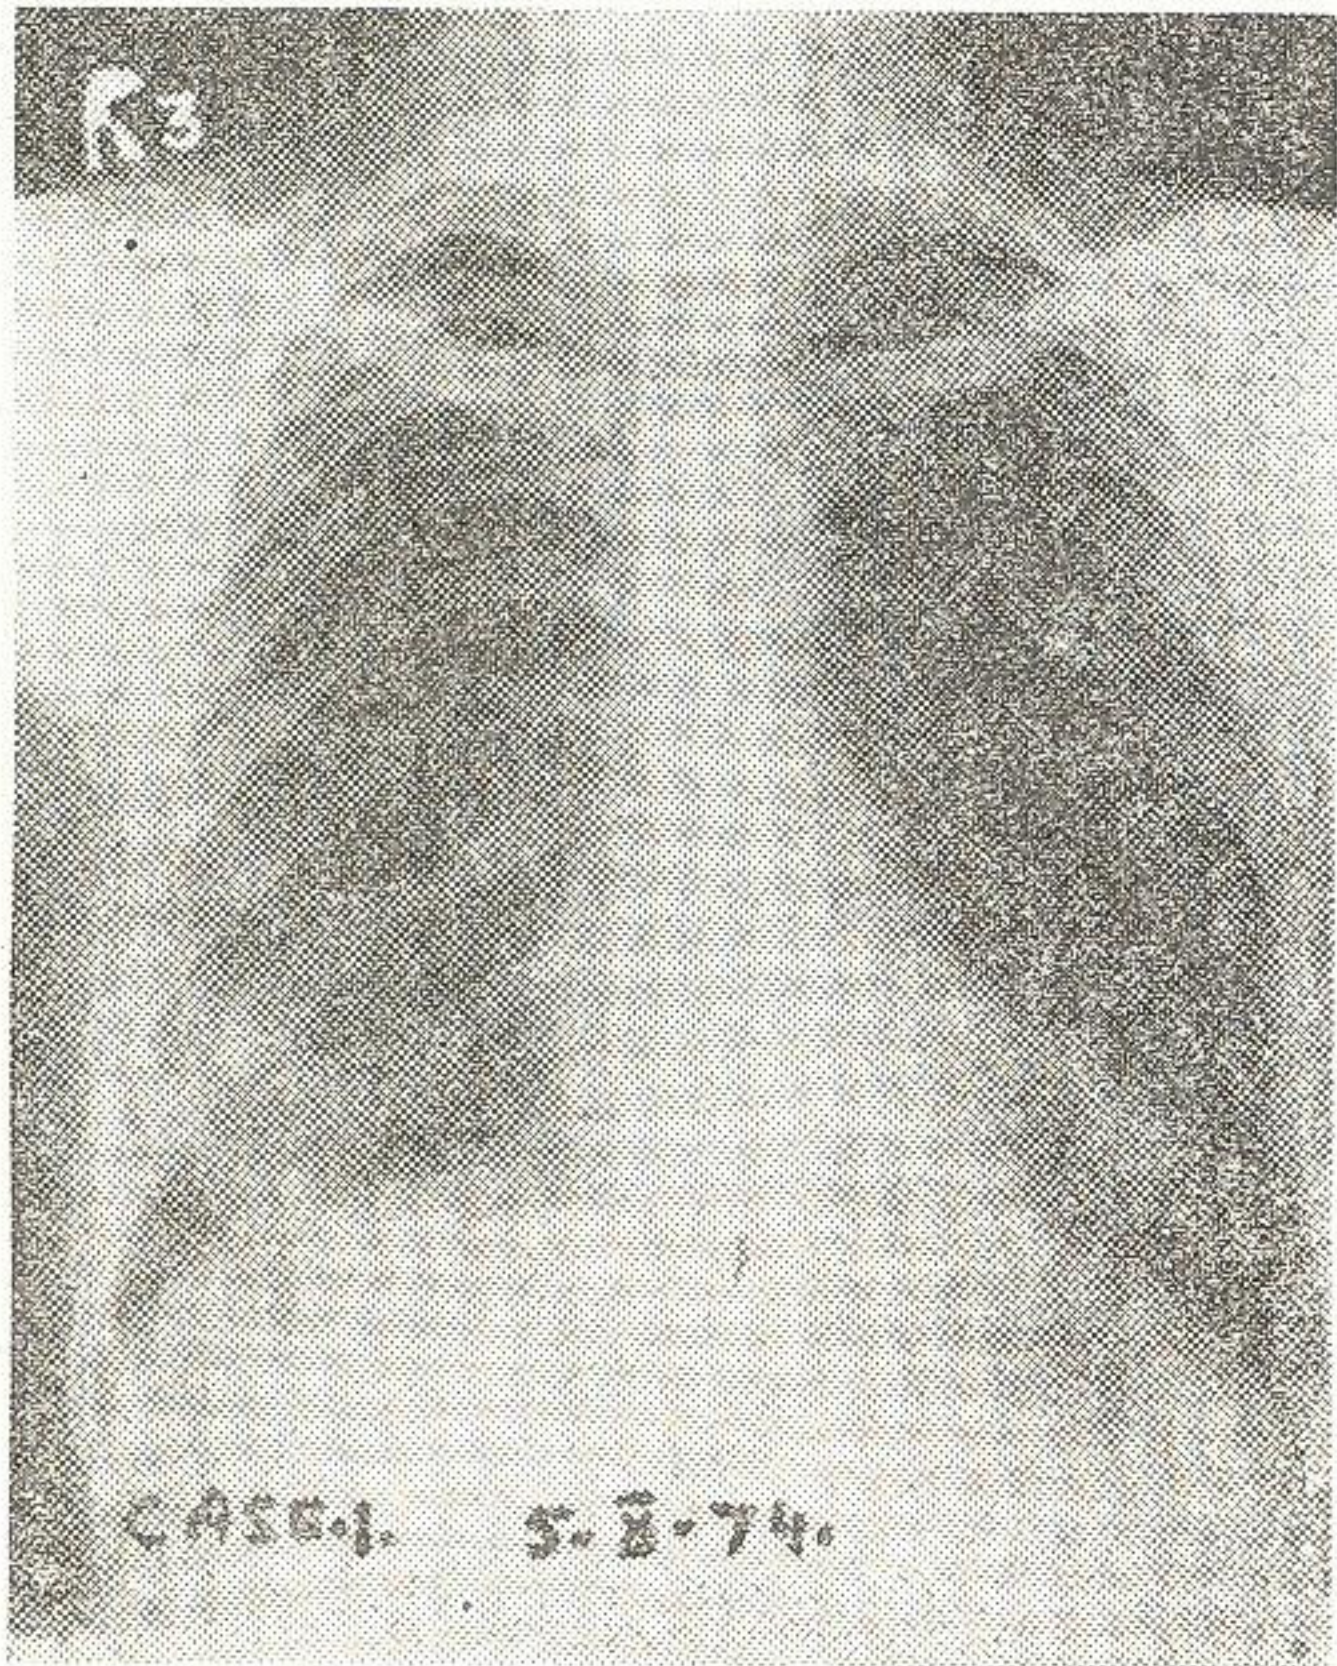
Case 1 (5-10-1974). X-Ray chest showing complete clearance of the amebic empyema without any residual signs. The right diaphragm is at normal level.
